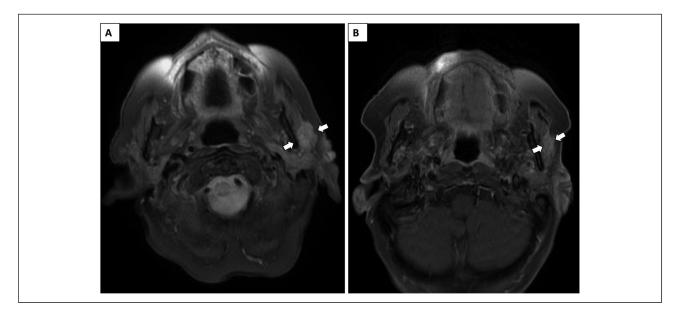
Magnetic resonance imaging (MRI) of face and neck showing the left parotid mass. A = Baseline imaging. B = Postneoadjuvant therapy restaging scan. The tumor has decreased in size from 16 mm to 11 mm, meeting RECIST criteria of partial response (> 30% reduction in length of the longest axis).
